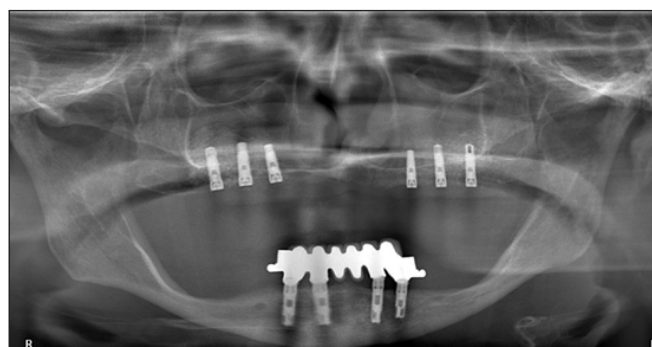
Panoramic view of the dental implants. This is the panoramic radiograph that was taken following the placement of 6 dental implants.
